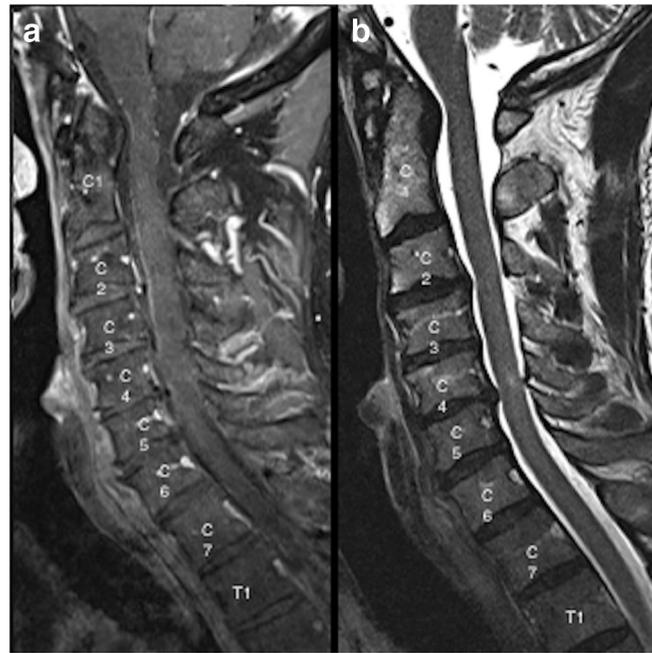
Magnetic resonance imaging (MRI) images of the cervical spine showing sagittal views of a largely resolved cervical cord mass. T1-weighted, gadolinium-enhanced (panel a) and T2-weighted (panel b) images of the cervical spine were taken approximately 1.5 years after treatment.
